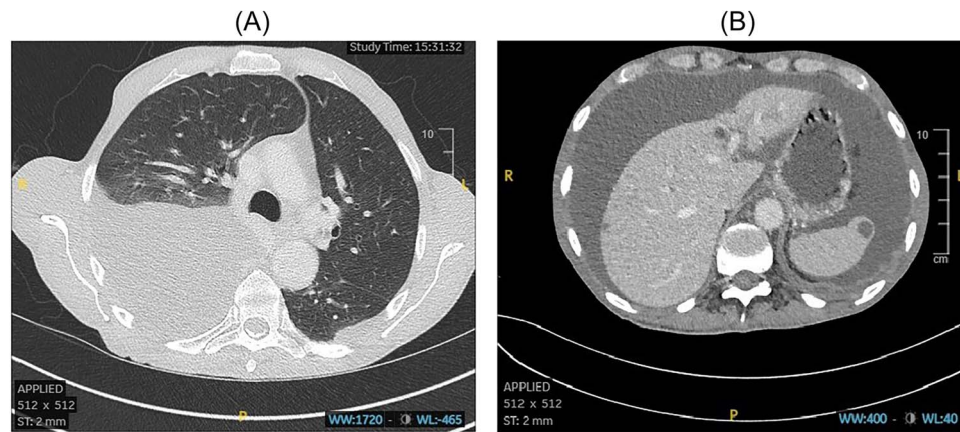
Computed tomography demonstrating (a) large right-sided pleural effusion with surrounding atelectasis and (b) significant abdominal ascites with benign liver and splenic cysts.
